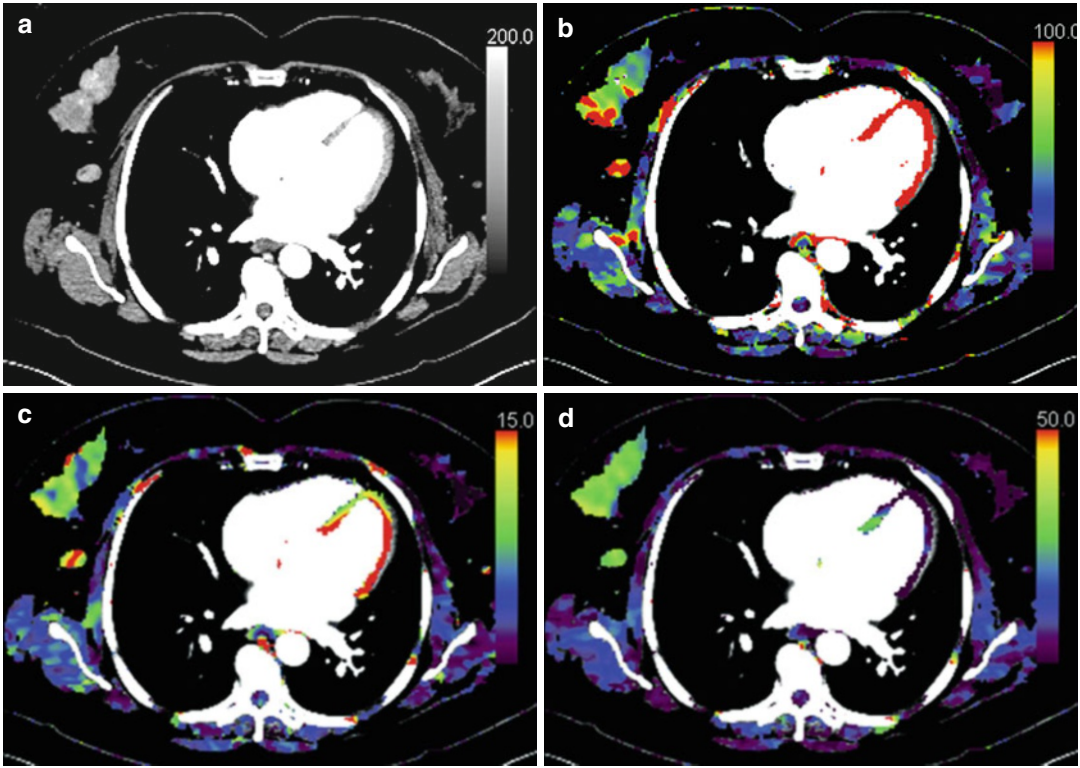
Perfusion CT image of a right breast cancer (a) and corresponding parametric maps of regional blood flow (b), blood volume (c) and extraction fraction (d) are shown. The tumour demonstrates heterogeneous blood flow and blood volume
